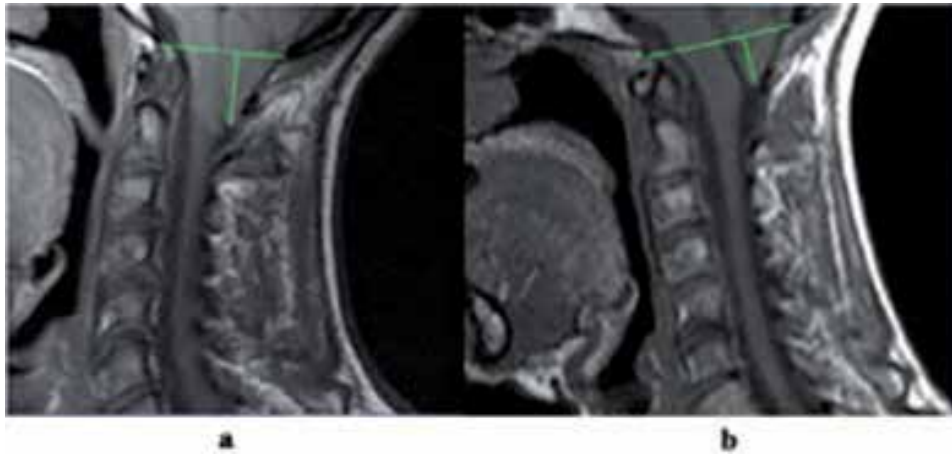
Preoperative (a) and postoperative (b, at 7 years) magnetic resonance images of a 49-year-old female patient with Chiari malformation type I, operated of filum terminale sectioning, with impressive improvement of the tonsillar descent from 17 to 13 mm with respect to McRae's line (measured in the cuts with maximal descent).
